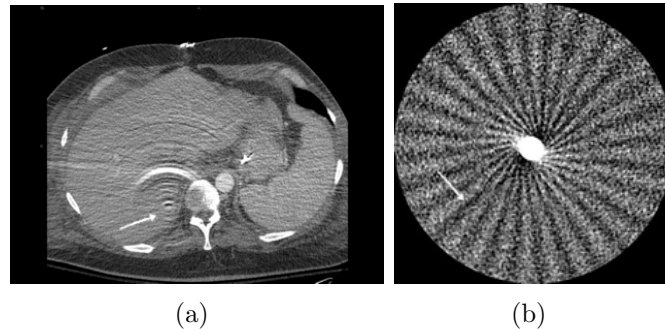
Example of scanner-based CT artifacts: (a) ring artifacts inside the abdomen [<http://www.upstate.edu/radiology/education/rsna/ct/artifact.php>] and (b) CT image of an acrylic sphere showing windmill artifact [Barrett and Keat, 2004].
